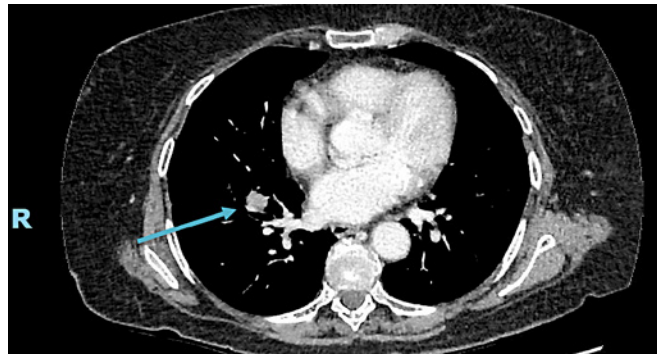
CT scan of the chest showing a small tumour mass in the right lower lobe.
